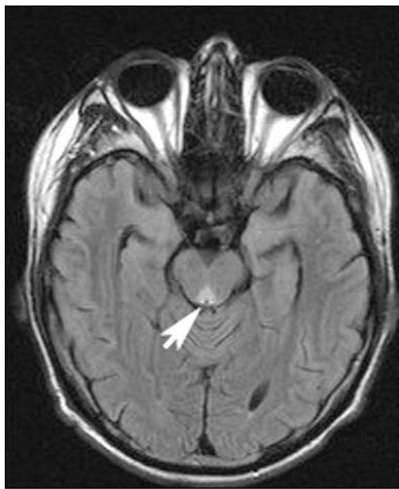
Axial FLAIR image at level midbrain level demonstrating abnormal high signal in the periaqueductal grey area (arrow).
